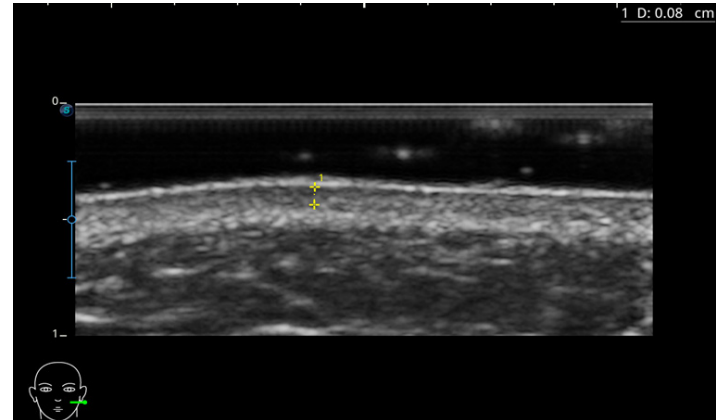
Post-injection ultrasound pattern following product placement. Note the changes compatible with biostimulation, characterized by a homogeneous granularity, as well as a clearly discernible moderate increase in the subepidermal low echogenic band (SLEB).
